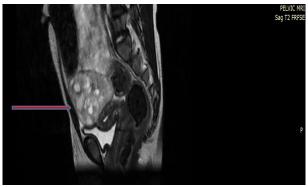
Sagittal view of Pelvic MRI (T2) showing a round heterogeneous mass (arrow) with multiple focal cystic areas in the left pelvic cavity
